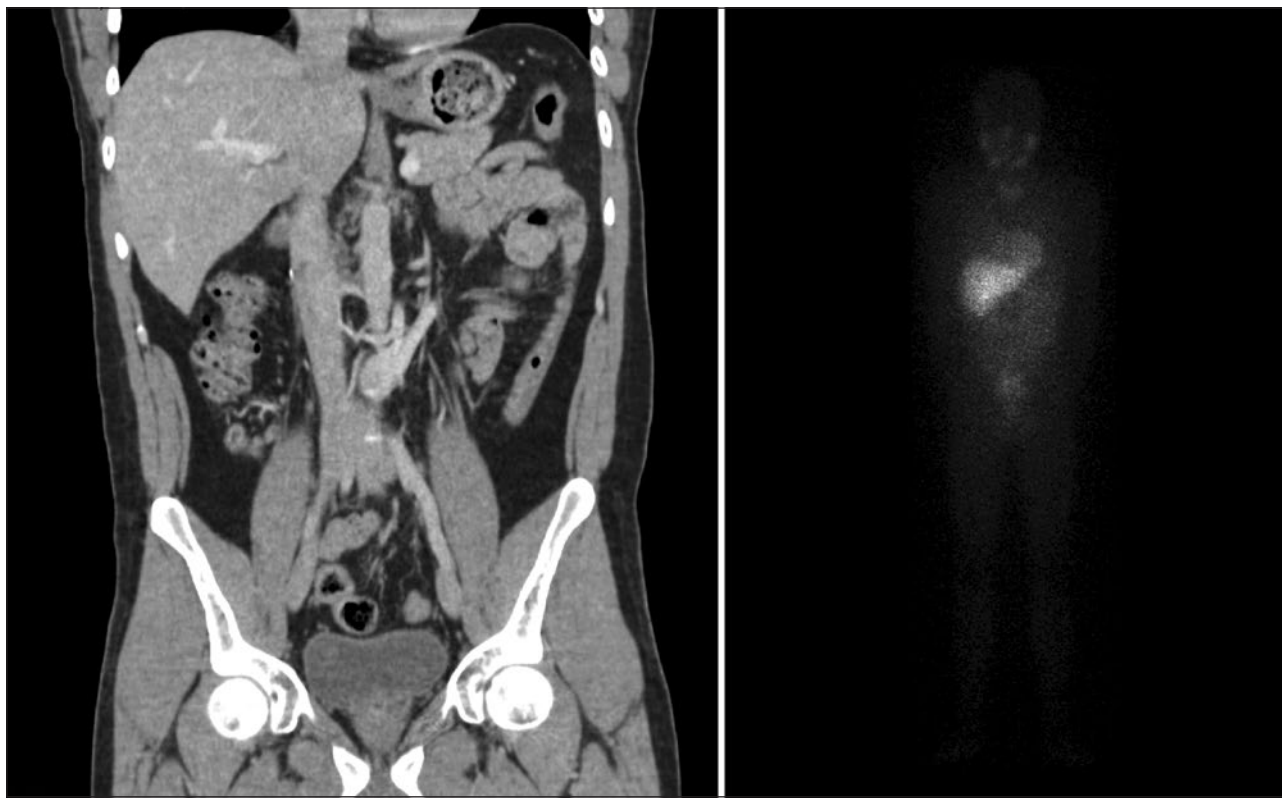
Post-surgical computed tomography without evidence of residual mass (A), and MIBG scintigraphy with no abnormal uptake (B).
